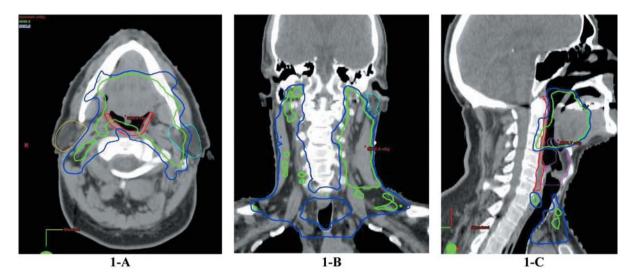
A, B and C: Axial, coronal, and sagittal CT views, respectively of the oropharynx targeted by radiotherapy. The 60 Gy (green isodose line), and 54 Gy (blue isodose line) were prescribed to high risk ipsilateral involved neck, oropharynx, and low risk neck (uninvolved neck, lateral retropharyngeal nodes and bilateral low neck), respectively.
